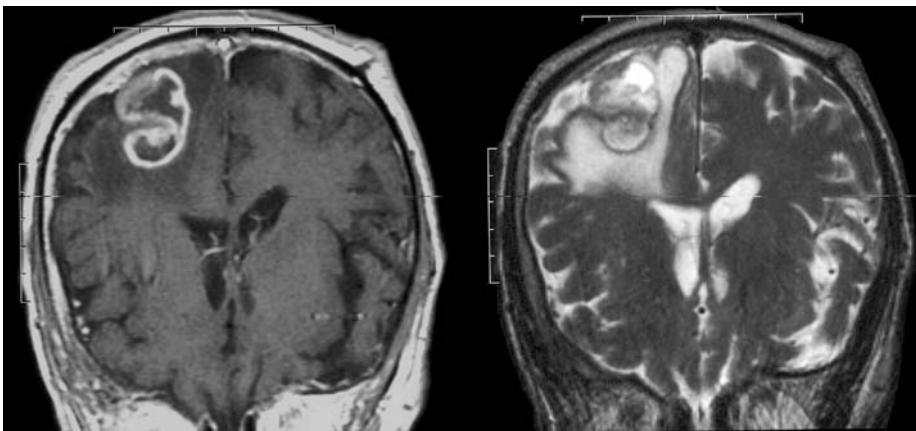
Glioblastoma. A T1-weighted MRI with marked gadolinium-enhancement, indicating neovascularization and vascular permeability. B T2-weighted MRI reveals extensive perifocal edema.
